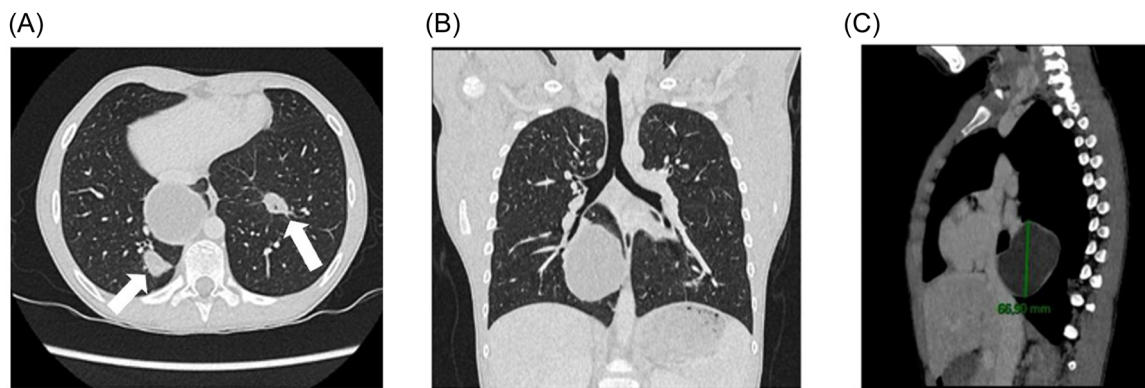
The chest Computed Tomography ([A] parenchymal axial section, [B] parenchymal coronal section, [C] mediastinal sagittal section) revealed a large mass in the lower lobe of the right lung with a cystic component and fluid density and two smaller pseudo-nodular lesions (one the right lower lobe and the other one in the left lower lobe underlined in [A] by the white arrows). [Color figure can be viewed at wileyonlinelibrary.com]
